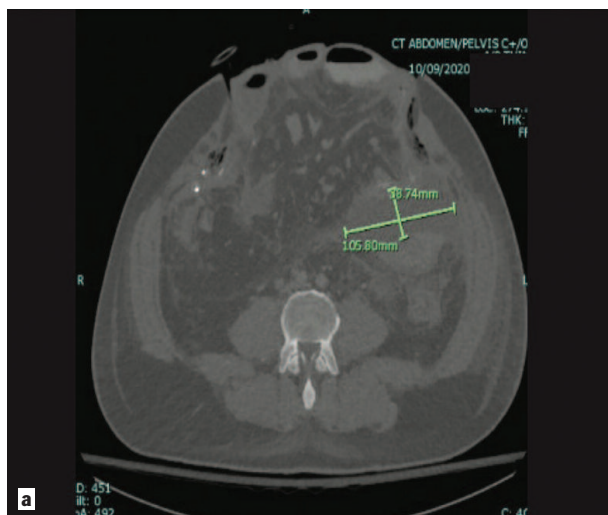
CT scan of a patient with intra-abdominal catastrophe. b) Entire abdomen as one large inflammatory mass.
